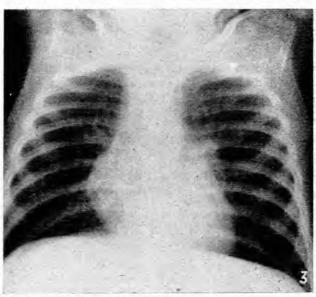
Cynthia. Normal X-ray of chest.
